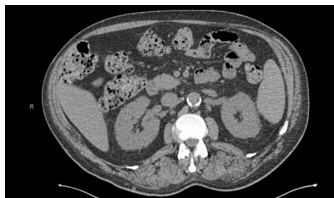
Computed Tomography of the abdomen and pelvis revealed no renal calculi, no hydronephrosis, and no ureteral calculus.
